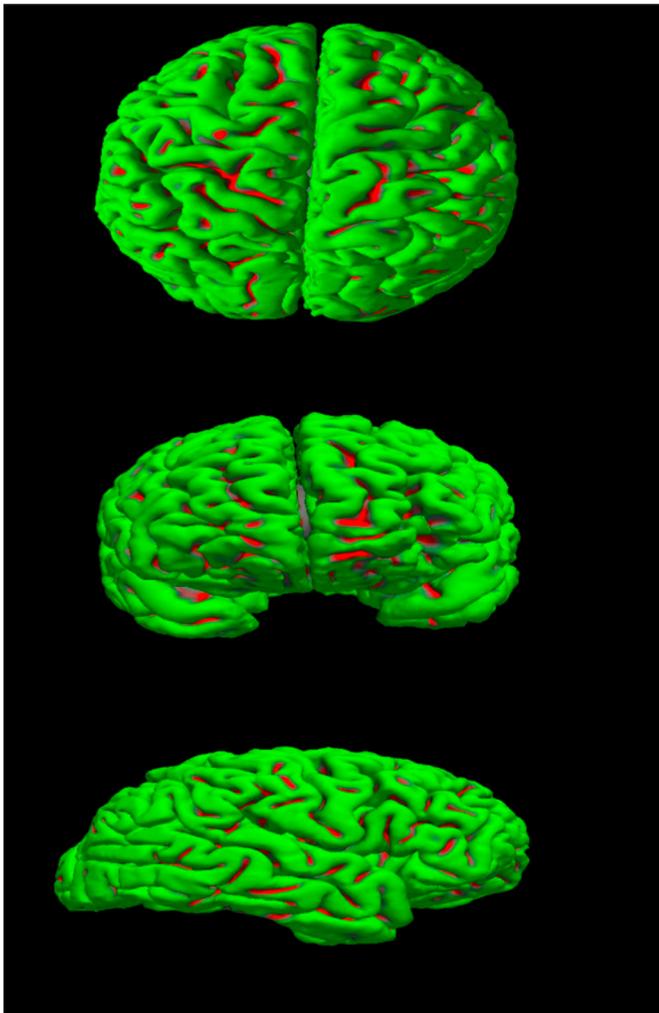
3D- Visualization of the whole brain from baseline MRI of an HCV patient.
